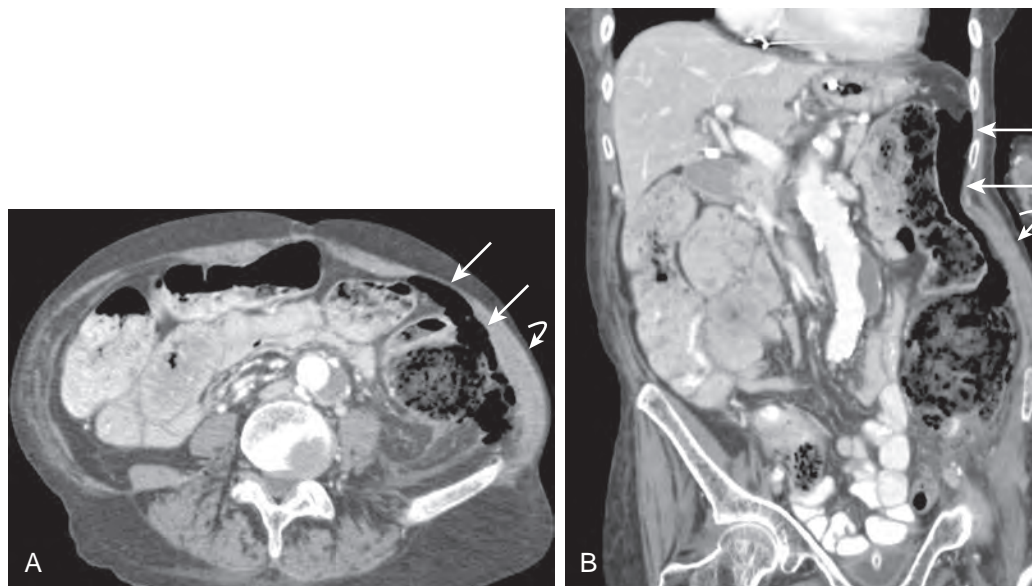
Colonic perforation from stab wound. A 65-year-old man presented with a stab wound to his left flank. A. Axial CT scan of the abdomen and pelvis reveals free intraperitoneal air (*straight arrows*) with discontinuity of the descending colonic wall, compatible with traumatic colonic perforation. Note is also made of a hematoma within the left flank musculature at the site of the stab wound (*curved arrow*). B. Coronal reconstruction of the CT image again reveals free intraperitoneal air (*straight arrows*) and left flank musculature hematoma (*curved arrow*). Incidental note is also made of an abdominal aortic aneurysm.
